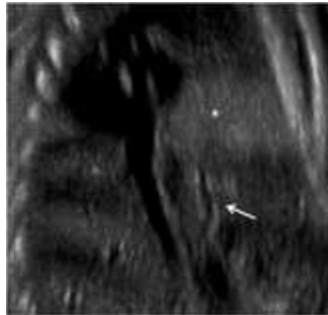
Gray-scale ultrasound of the same patient performed prenatally also demonstrates the anomalous arterial feeder originating from the upper abdominal aorta. The left lower lobe sequestration is partially visualized (*).
